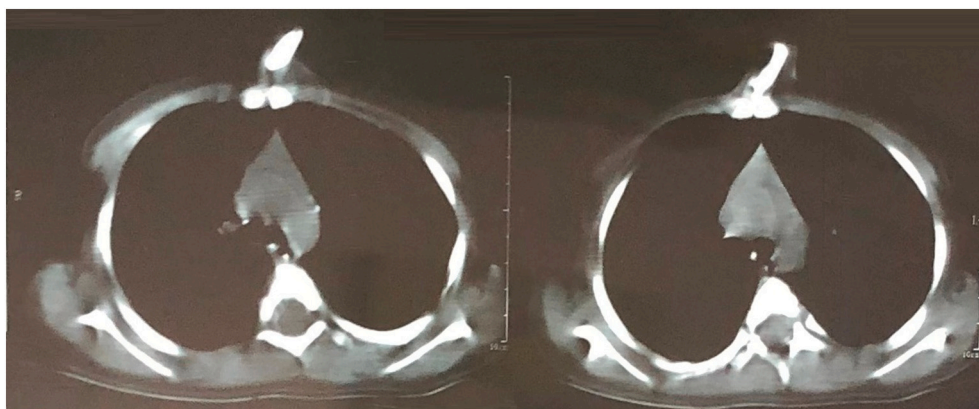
A computed tomography of the chest showing an abnormal bone articulated with the anterior face of the sternum.
